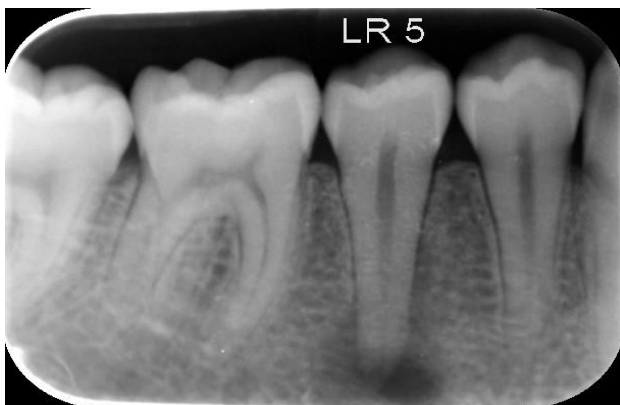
Radiograph revealing periapical radiolucency around tooth 29.
